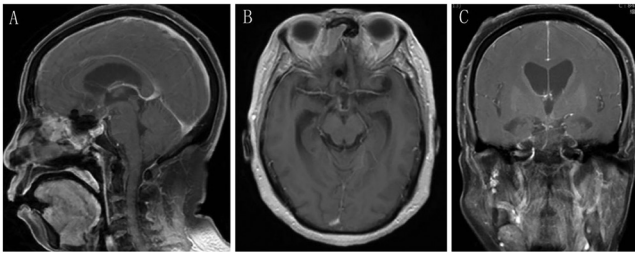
(A) Sagittal, (B) axial and (C) coronal images of enhanced MRI at the postoperative review. The result indicated complete tumor resection.
